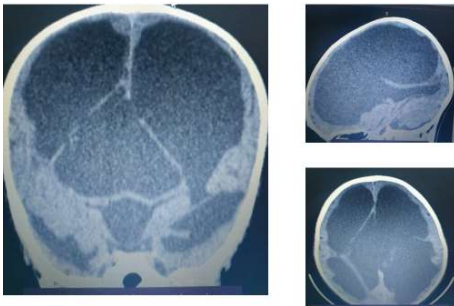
Showing CT scan images of massive hydrocephalus with triventriculomegaly.
